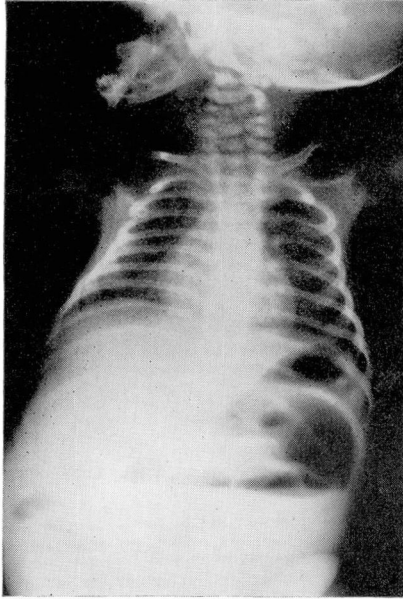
Plain roentgenogram of the abdomen in the upright position, showing small-bowel obstruction, and multiple fluid levels, in a six and one-half week old infant who had diarrhea since birth, and persistent vomiting, with distended abdomen. Operation disclosed a circumferential stenosing ulcer 6 in. proximal to the ileocecal valve. There was no evidence that the lesion was congenital.
